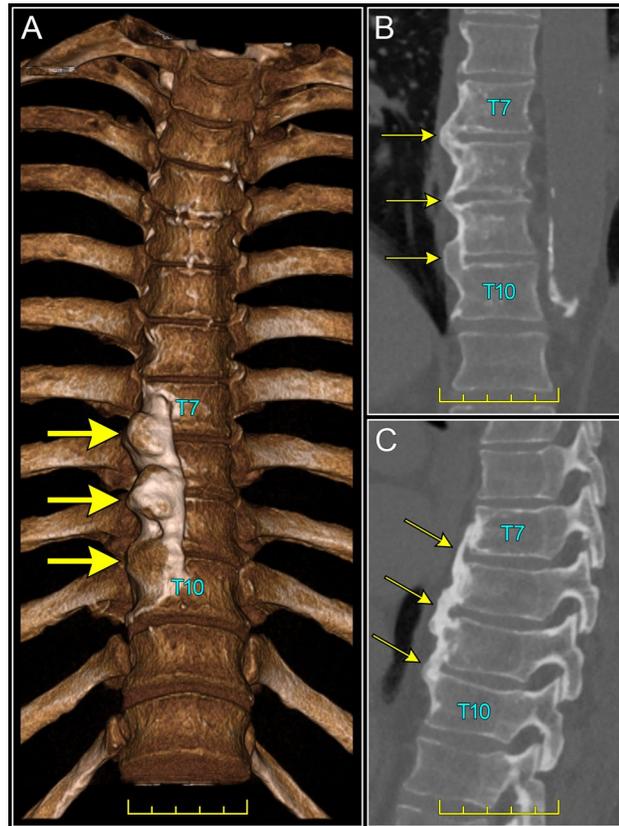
Representative clinical computed tomography images of a 69-year-old male individual with DISH that was documented in the radiology report
